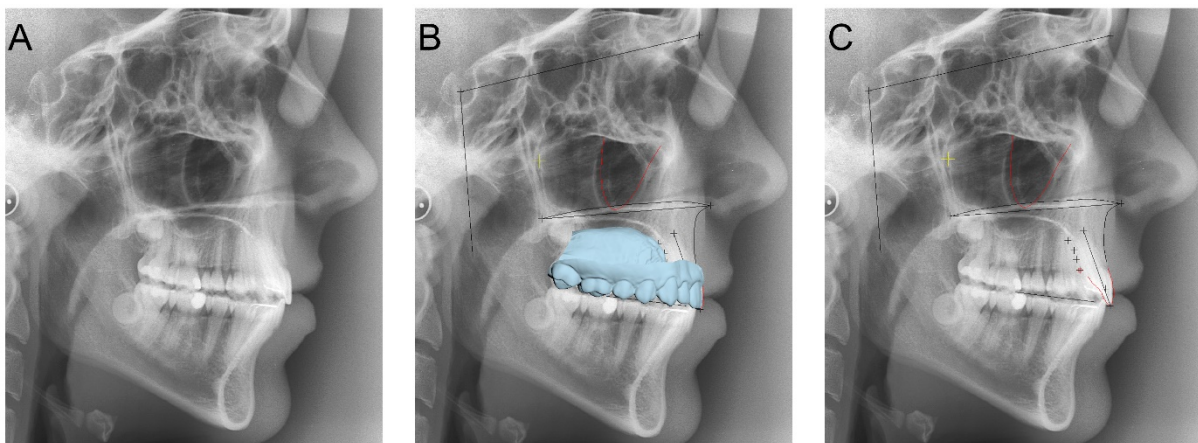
A. Post-treatment cephalometric radiograph. B. Post-treatment maxillary dental cast, registered on the corresponding cephalometric radiograph to facilitate the placement of the papilla and rugae points. C. All reference planes, curves, and landmarks placed on the cephalometric radiograph for the needs of the study. Detailed description is provided in Supplementary Table 2.
